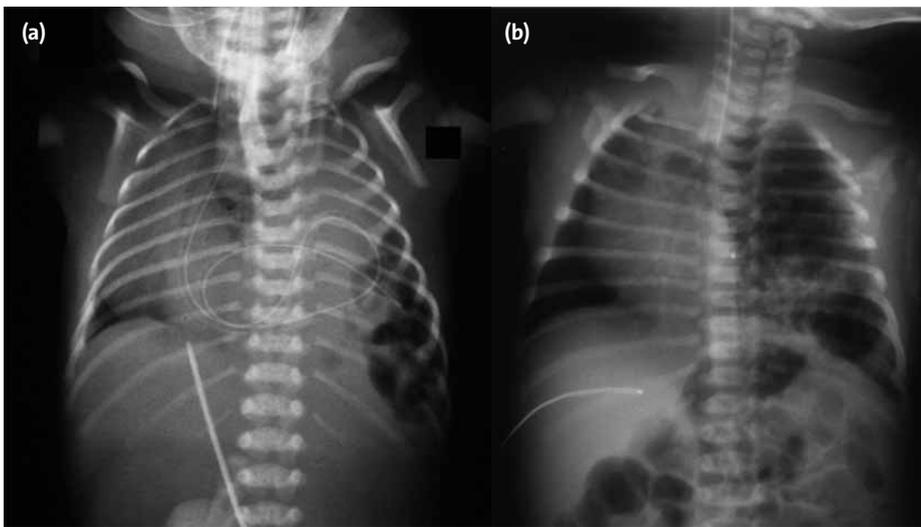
Chest X-rays of a left congenital diaphragmatic hernia (a) and a left lower lobe congenital cystic adenomatoid malformation (b). Mediastinal shift to the right and left lung changes are seen in both cases. In the congenital diaphragmatic hernia the nasogastric tube is seen within the stomach in the chest and there is no bowel gas below the diaphragm. In the CAM the left diaphragm appears intact and there is a normal bowel gas pattern in the abdomen.
